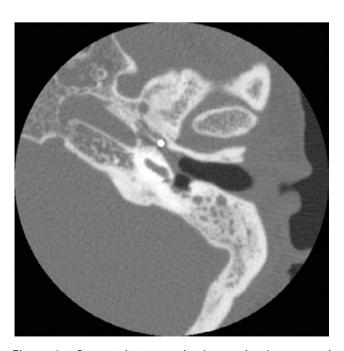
Computed tomography image showing a round foreign body in the left eustachian tube.
